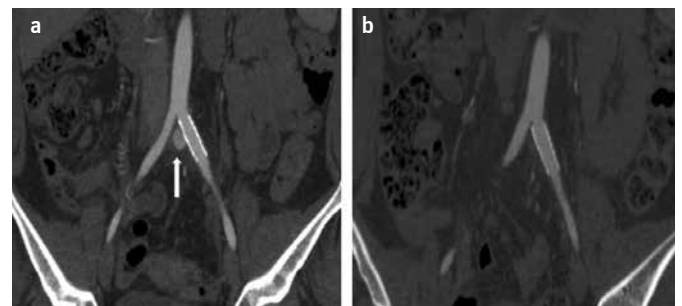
a, b. Coronal abdominal CT showed covered left iliac artery stent and it demonstrated early enhancement of the left common iliac vein aneurysm due to minimal leakage (arrow) (a). Aneurysm and leakage was not revealed at follow-up 1 month later (b).
